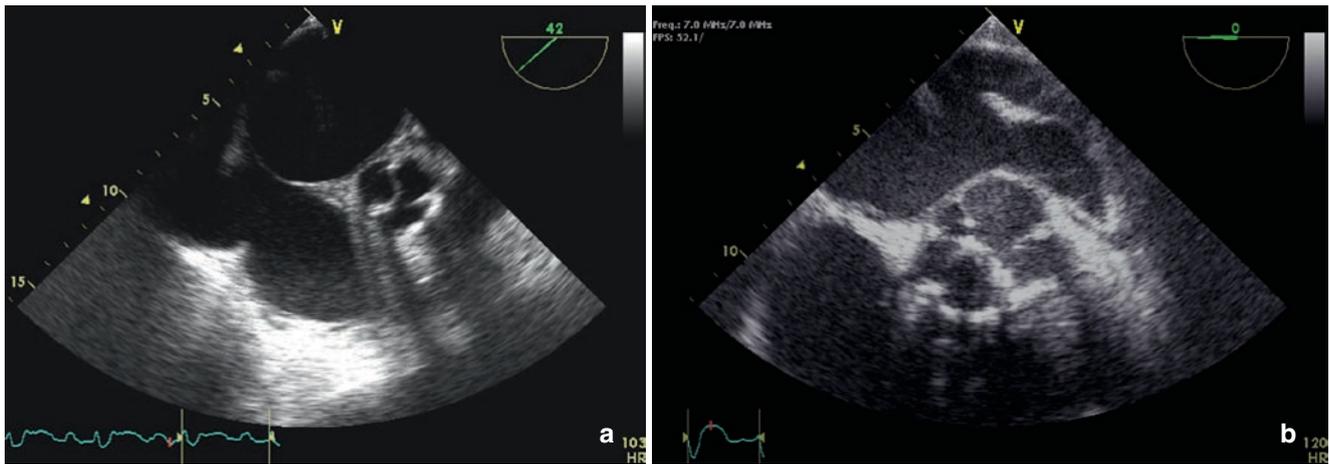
At early stages, abscess appears as a thickening of the aortic wall, which is difficult to differentiate from haematoma (a). However, a trans-oesophageal echocardiogram repeated 5 days later
